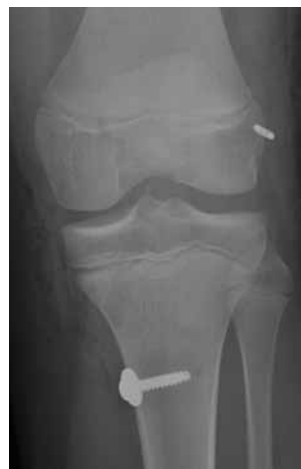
Anteroposterior radiograph after physal-respecting partial transphyseal anterior cruciate ligament reconstruction with transphyseal tibial tunnel and intraepiphyseal femoral tunnel.
